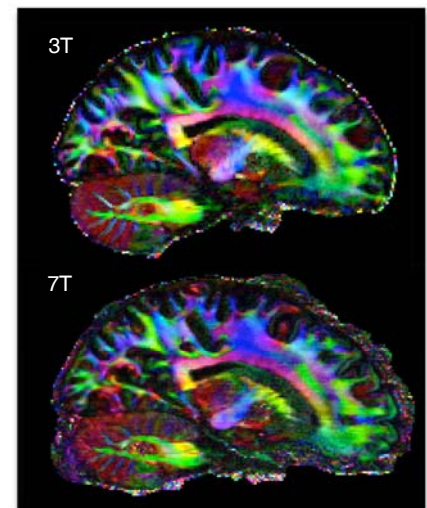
3T vs 7T whole brain MRI (Principal direction of diffusion).
